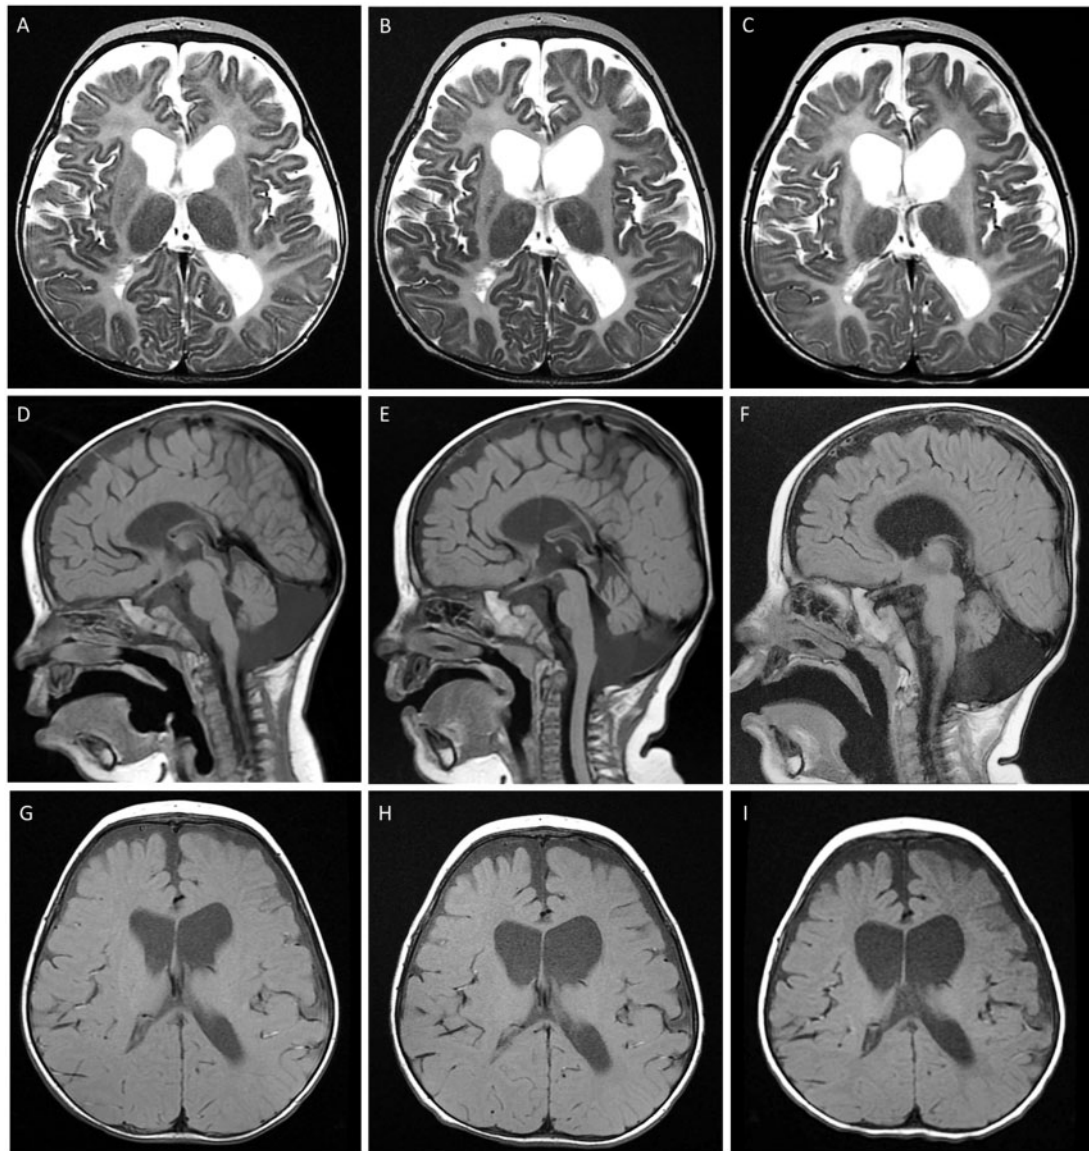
MRI images at 6 (A, D, G), 11 (B, E, H), and 17 (C, F, I) months of age. (A–C) Decreasing size of the caudate and putamen and enlargement of ventricles. Also evident is the lack of myelination, with the parieto-occipital regions more affected than anteriorly. (D–F) Progressive atrophy of the cerebellum and thin corpus callosum. (G–I) Lack of progression of myelination.
